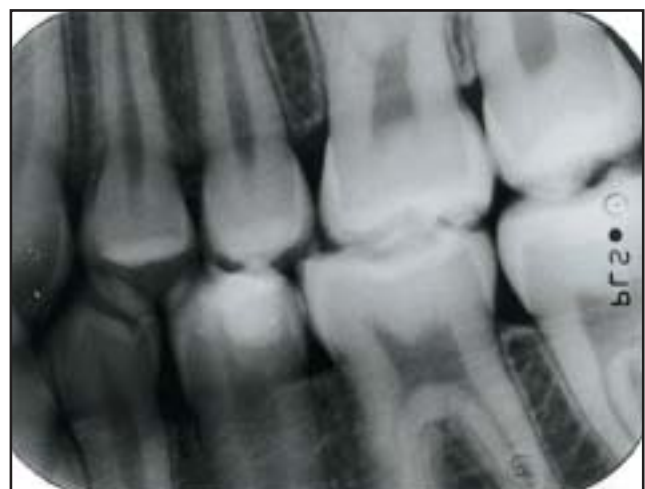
Post-operative bitewing radiograph two months following treatment.
